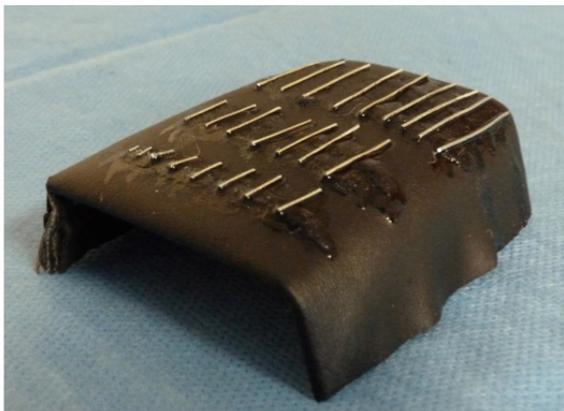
Custom radiographic scale.
